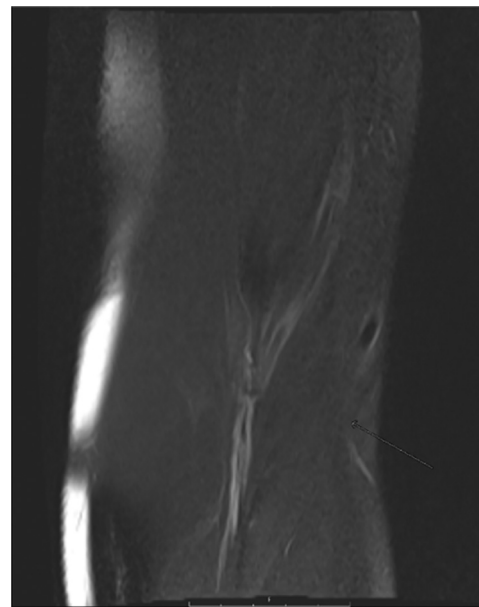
Pre-exercise coronal fat saturated T2 MRI sequence of the patient's forearm, demonstrating the neurovascular bundle centrally without evidence of increased signal intensity in muscle.
